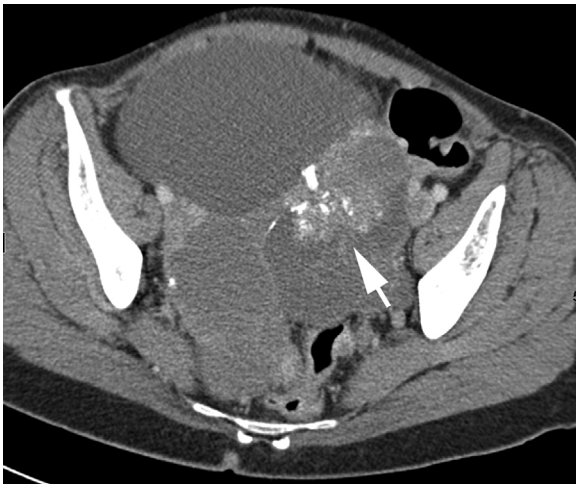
Low grade serous carcinoma with co-existing serous borderline tumor. Patient 8 is a woman in her 60s. CT with intravenous contrast shows a primarily cystic pelvic mass with partially calcified soft tissue component (arrow).
